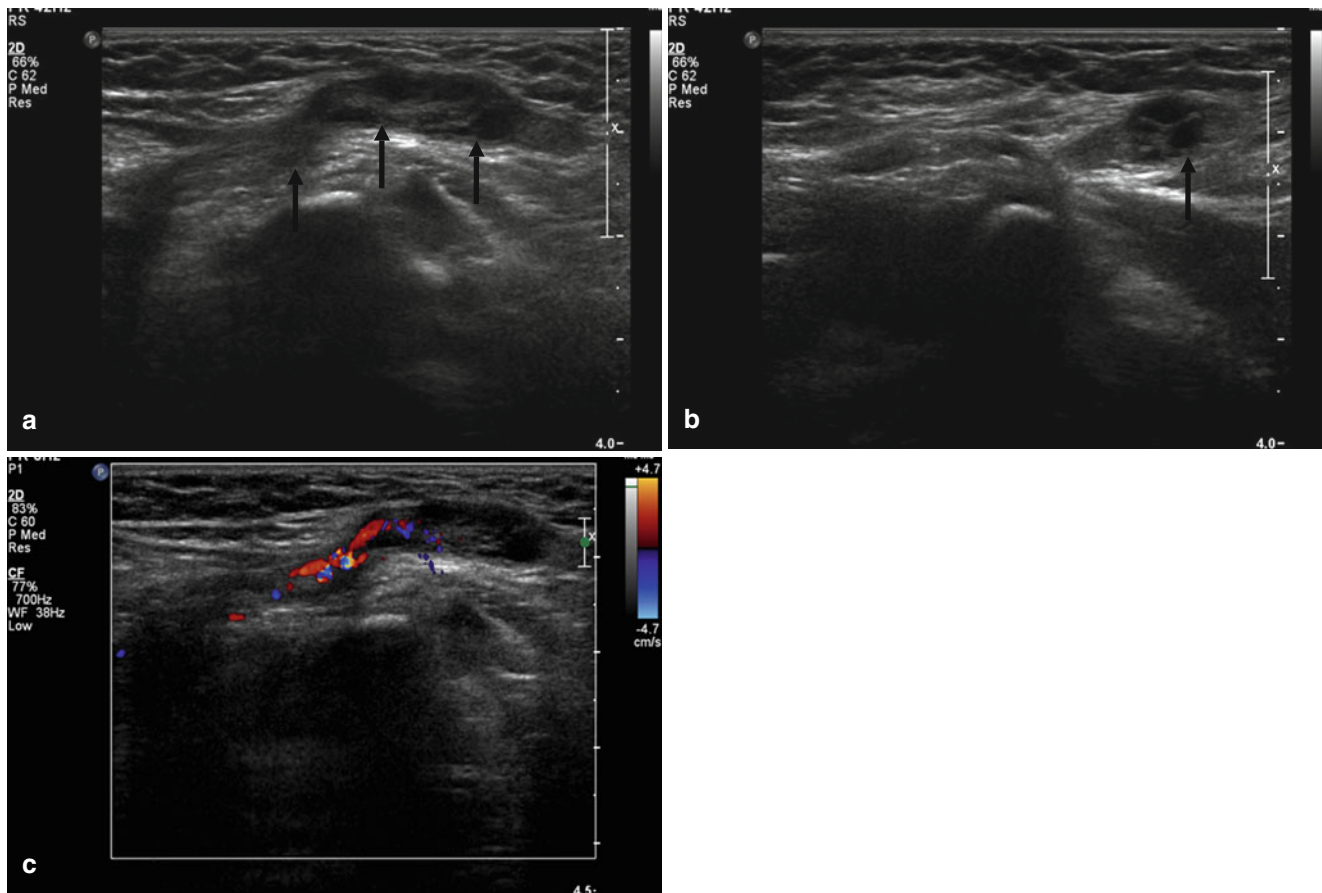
Ovary herniation into the inguinal canal in a 1-year-old girl. Longitudinal (a) and transverse (b) US images of the left inguinal canal show a herniation of ovary with peripheral small follicles. Color Doppler (c) US demonstrates flow signals in the pedicle of the ovary.
